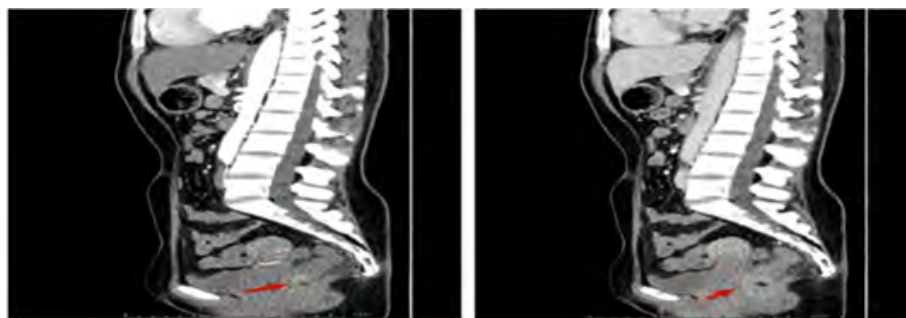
Contrast-enhanced CT results. The local intestinal wall becomes thickened at the junction between the lower rectum and the anal canal, with patchy enhancement and blurry fat around the intestinal wall (red arrow). The left image is arterial phase, and the right is venous phase.
